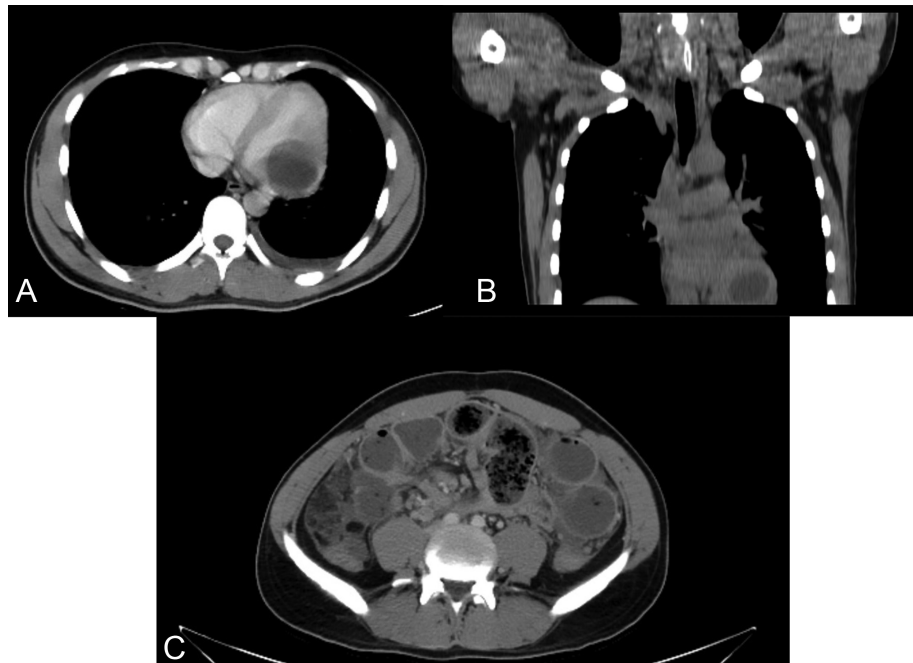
A–C. Computed tomography imaging of the thorax and abdomen. (A) Axial plane shows the hypodense cystic lesion on the left ventricle. (B) Coronal plane shows the cystic structure in the mediastinum. (C) Axial abdomen plane shows the peritoneal carcinomatosis and nodular lymph nodes.
